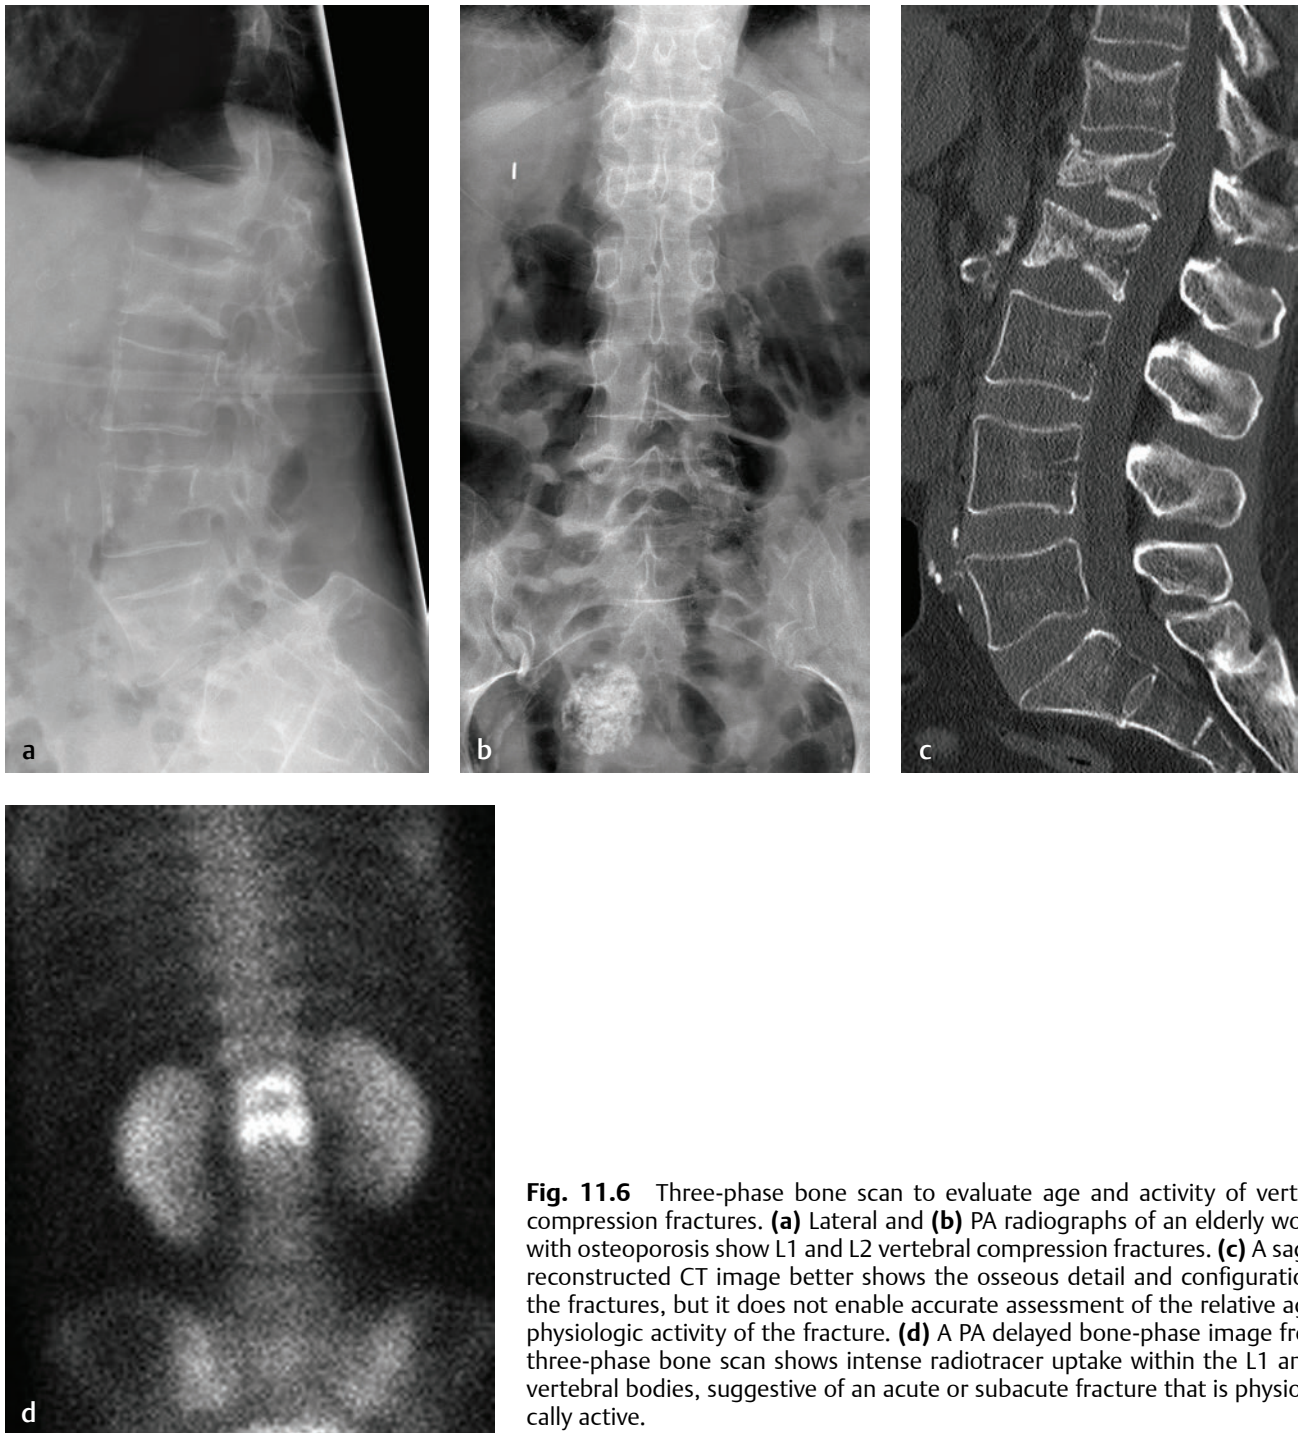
Three-phase bone scan to evaluate age and activity of vertebral compression fractures. (a) Lateral and (b) PA radiographs of an elderly woman with osteoporosis show L1 and L2 vertebral compression fractures. (c) A sagittal reconstructed CT image better shows the osseous detail and configuration of the fractures, but it does not enable accurate assessment of the relative age or physiologic activity of the fracture. (d) A PA delayed bone-phase image from a three-phase bone scan shows intense radiotracer uptake within the L1 and L2 vertebral bodies, suggestive of an acute or subacute fracture that is physiologically active.
